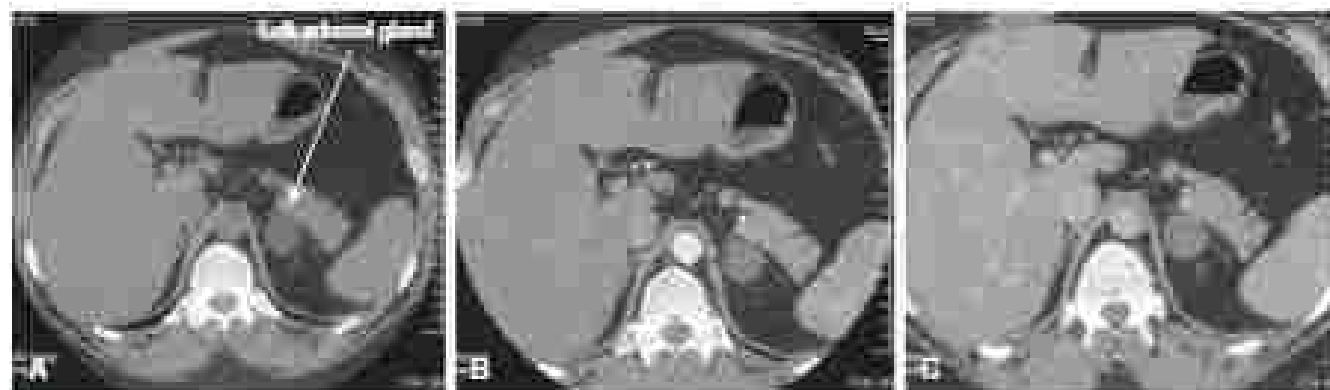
Adrenal protocol computed tomography (CT) scan. (A) Total venous contrast CT scan with this scan through the adrenal gland is checked. If the nodules or mass is homogeneous. Hemorrhagic units (HU) are measured. If HU within the nodules are > 10, contrast is administered and HU is again measured shortly thereafter. (B) Test again at 15 minutes. (C) A white percentage is then calculated.
